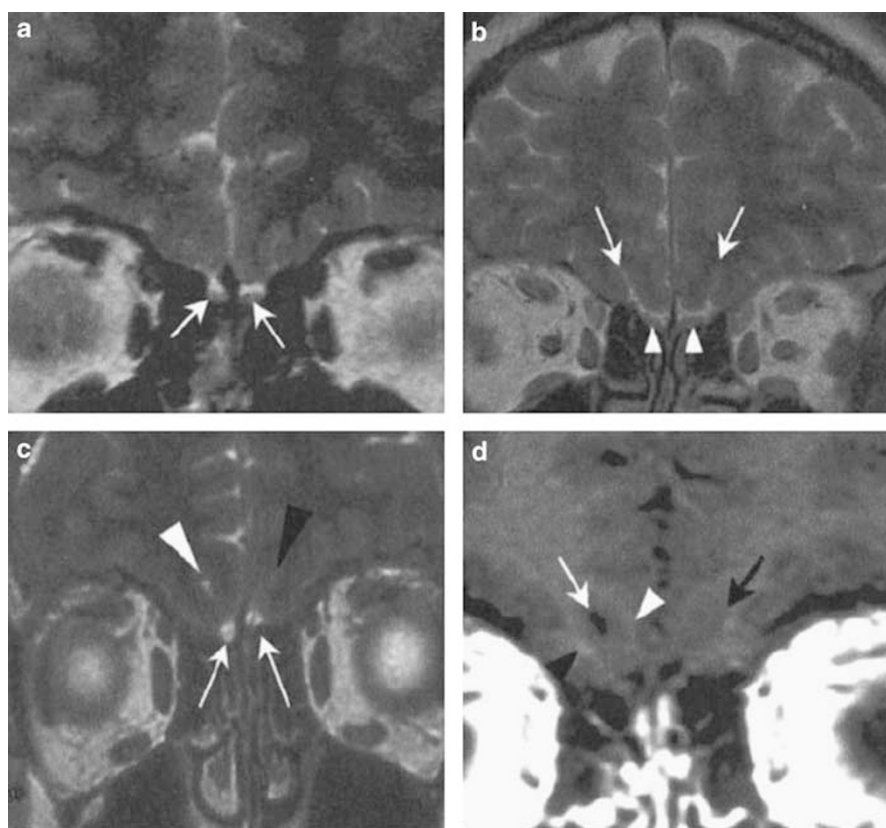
Cranial magnetic resonance imaging (MRI) of the olfactory bulb region in a control man (a and b) and a man affected by Kallmann syndrome (c and d). (a and b) MRI T2-weighted sequence in coronal plane shows normal olfactory bulbs in the control individual (a, white arrows), and posterior to the olfactory bulbs, good differentiation of the rhinal sulci (b, white arrows) and olfactory tracts (b, white arrowheads). (c) MRI T2-weighted sequence in coronal plane shows very small olfactory bulbs in the KS patient (white arrows). On the right side, the rhinal sulcus (white arrowhead) is visible, with good differentiation between the right gyrus and orbital gyrus. On the left side, there is no rhinal sulcus (black arrowhead), and no differentiation between the right and orbital gyri. (d) MRI T1-weighted sequence in coronal plane, posterior to olfactory bulbs, confirms the presence of the rhinal sulcus on the right side (white arrow), with a relatively good differentiation between the right (white arrowhead) and orbital (black arrowhead) gyri, and the absence of the rhinal sulcus on the left side (black arrow).
